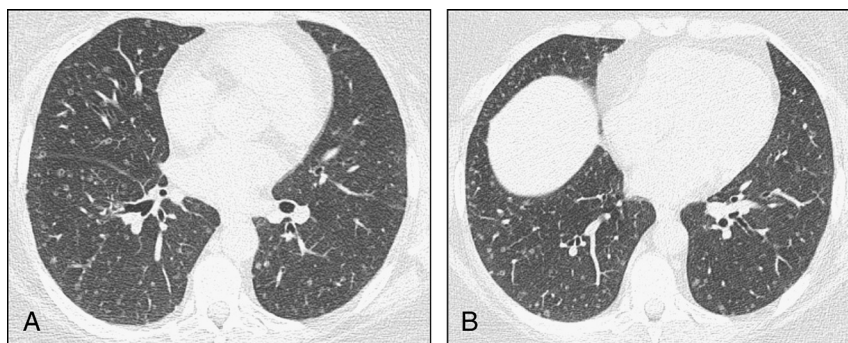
A, Thin-section, 1-mm, transaxial, unenhanced CT image in standard lung windows (L –700 Hounsfield unit; W 1500) at the level of the aortic valve showing multiple bilateral randomly distributed micronodules. Many nodules show central cavitation. B, More inferior section with the same technique showing slight asymmetry with greater concentration of nodules in the right lung. The nodules favor the lung periphery.
